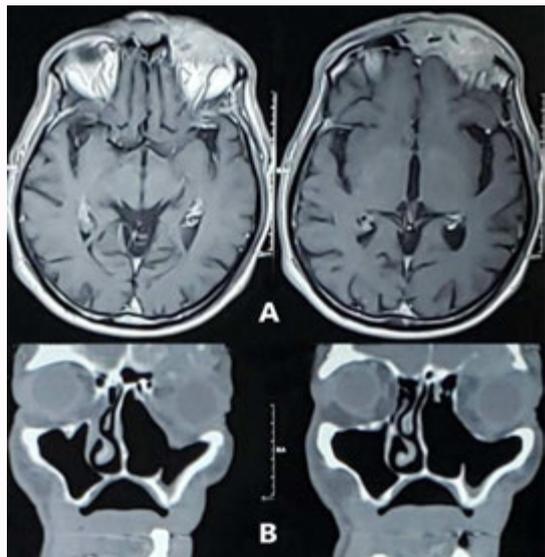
Computed tomography of the skull (A) and sinuses (B).
